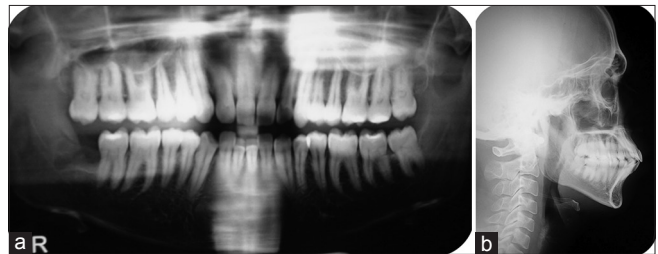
(a and b) Pretreatment radiographs
